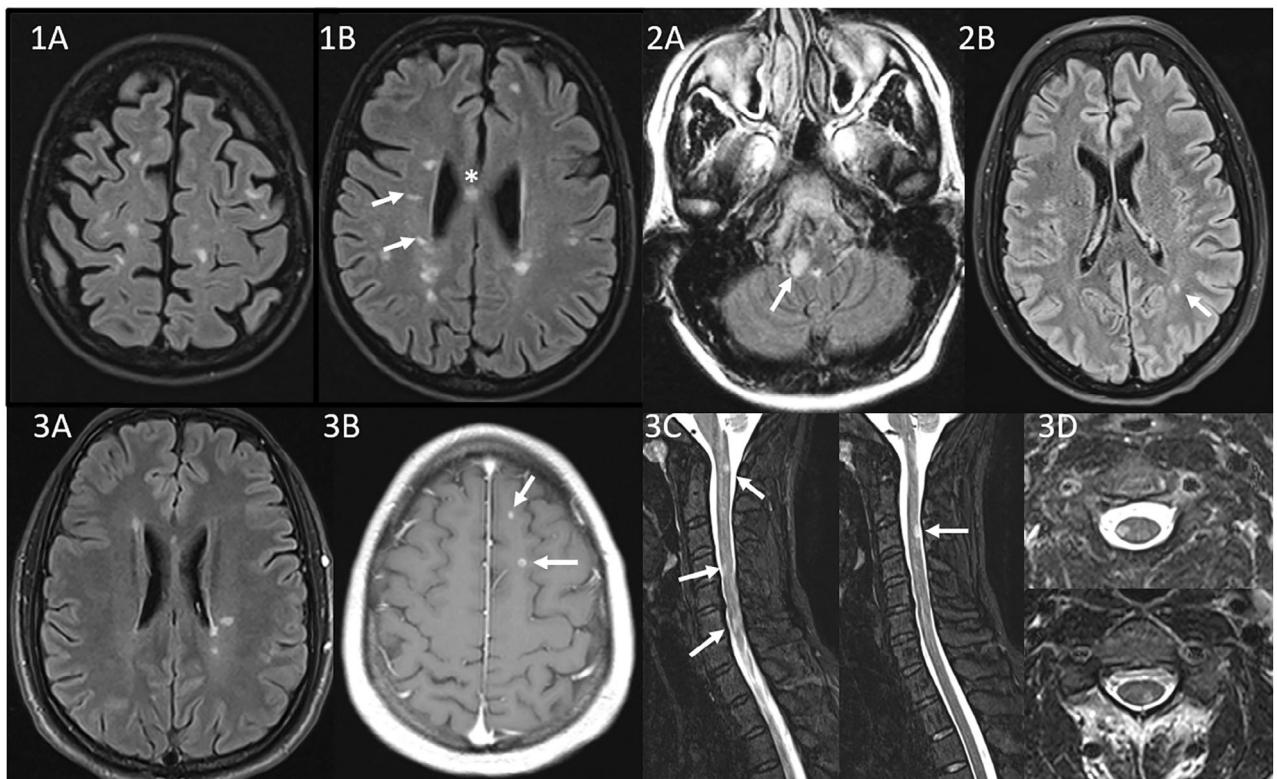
Radiological findings of myelin oligodendrocyte glycoprotein antibody-positive patients fulfilling McDonald 2017 criteria. (1A, B) Initial brain magnetic resonance imaging (MRI; transverse T2-weighted fluid-attenuated inversion recovery [T2-FLAIR] images) from Patient 1, showing several multiple sclerosis-like lesions involving the juxtacortical, subcortical, and periventricular white matter, including the corpus callosum (asterisk in 1B), some of them with an ovoid shape (arrows in 1B). (2A, B) Initial (2A) and 1-year follow-up (2B) transverse T2-FLAIR images from Patient 2. The initial brain scan showed a focal lesion in the medulla oblongata (arrow in 2A). The follow-up brain MRI demonstrated one small new T2 lesion in the left-brain hemisphere (arrow in 2B). (3A–D) Initial brain and cervical spine MRI from Patient 3. The brain MRI shows few multiple sclerosis-like lesions in the subcortical and periventricular white matter on T2-FLAIR images (3A), some of them showing contrast enhancement (arrows in 3B). The cervical cord MRI showed 4 short-segment lesions involving the lateral and dorsal columns on sagittal short tau inversion recovery (arrows in 3C) and transverse T2-weighted (3D) images.
